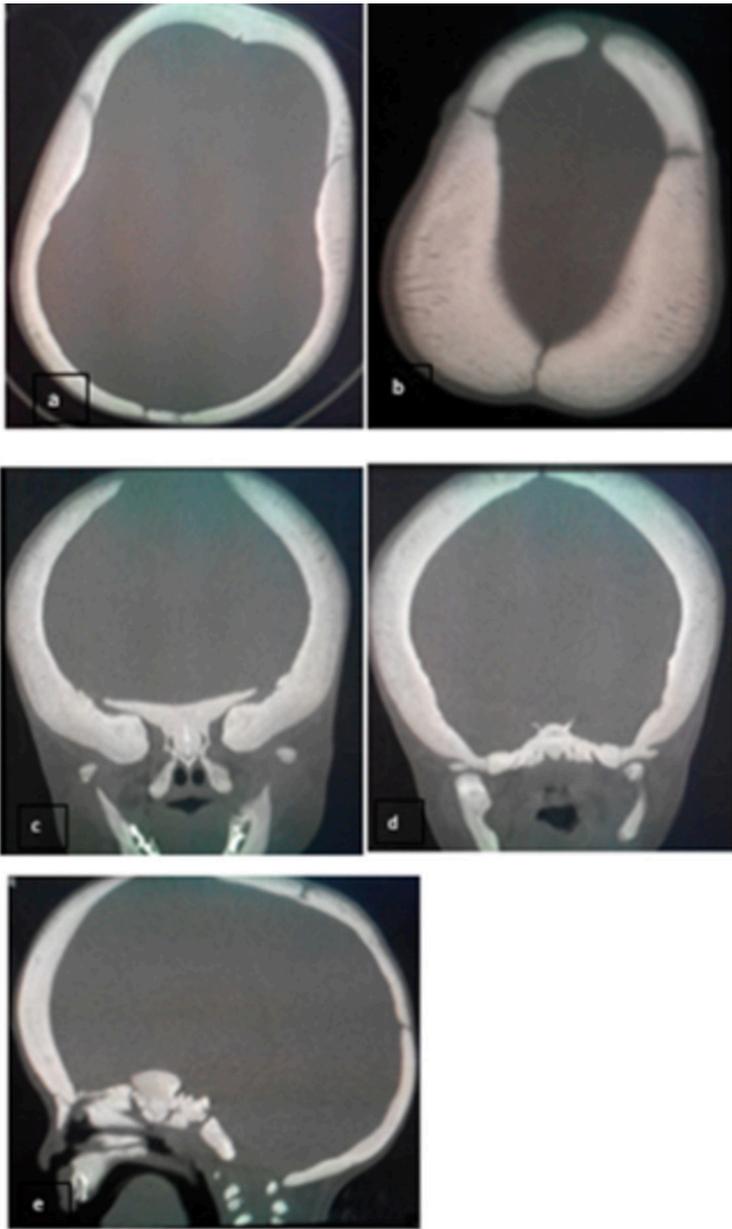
Head non contrast CT : axial (a,b) , coronal (c,d) and sagittal (e) : osteosclerosis and thickening of the cranial vault
